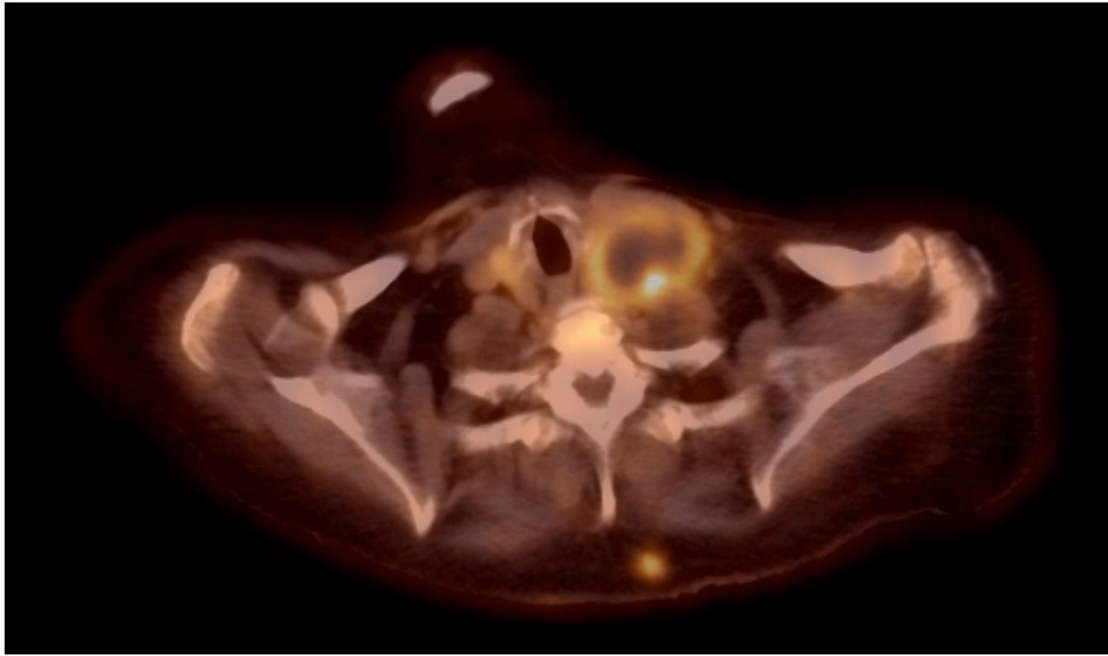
Axial section of positron emission topography–computed tomography demonstrating a prominent left-sided thyroid lesion.
